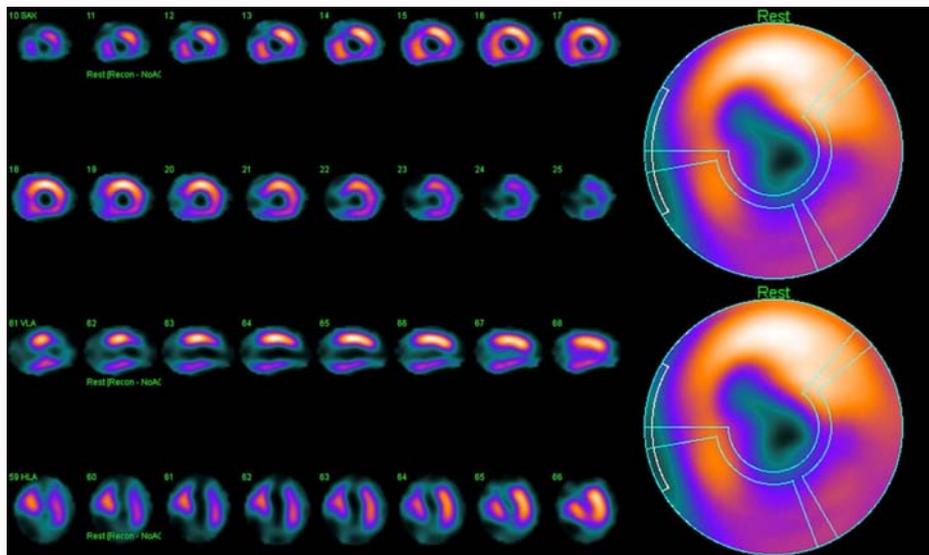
Gated-SPECT. Myocardial perfusion images showed a non-transmural perfusion defect from the apical to the basal third of the inferior wall and in the inferolateral region (Right Coronary Artery [RCA]/Circumflex Artery [Cx] territory), and a transmural apical and middle-third of anteroseptal perfusion defect, which extends as non-transmural to the middle-third of the septal and inferolateral walls (left anterior descending artery territory).
